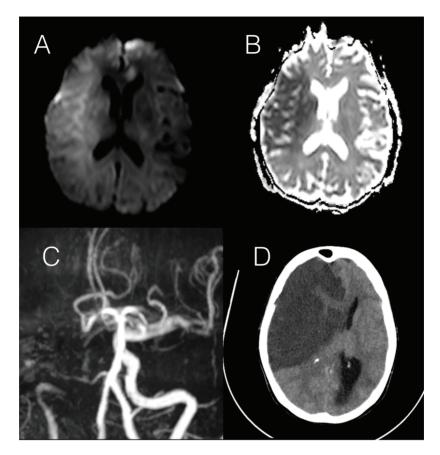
(A) Axial cranial magnetic resonance (MR) imaging diffusion weighted and apparent diffusion weighted imaging sequence showed a hyperintensity in the right frontoparietal area with (B) a corresponding signal drop in axial apparent diffusion coefficient sequence. (C) Time of Flight MR angiography shows absence of the distal part of the right internal carotid artery. (D) Plain axial computed tomography performed on day six showed a large hypodensity in the right ICA territory
